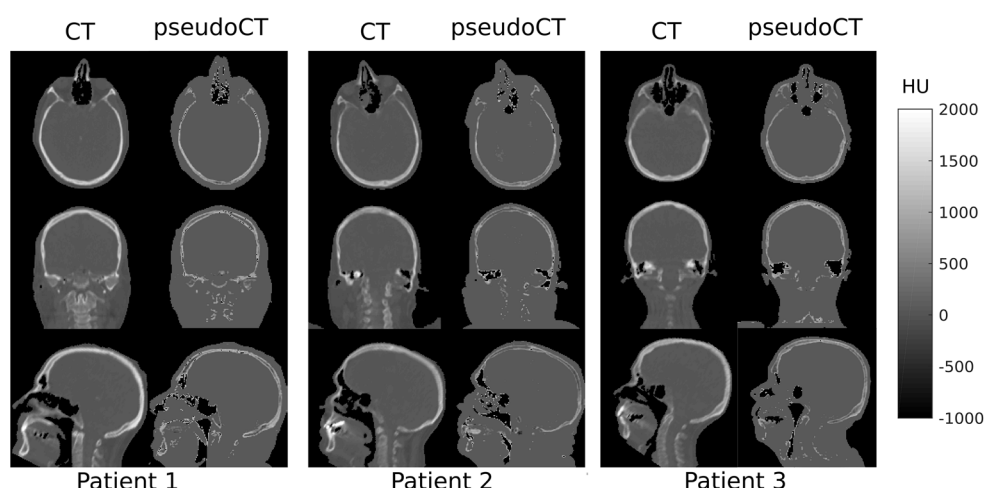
Three examples of CT images and ZTE-based pseudo-CTs generated using the segmentation algorithm and the linear relationship between normalized ZTE intensity and CT density in HU.
